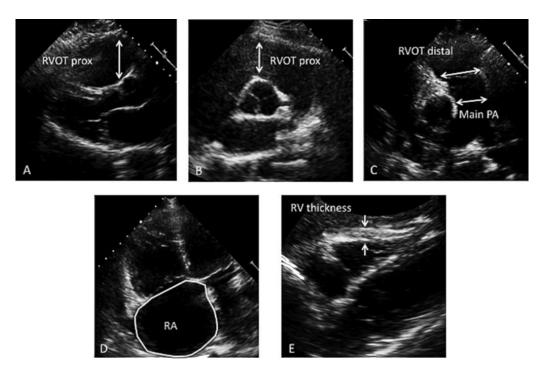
Examples of 2-dimensional echocardiographic chamber dimensions and RV wall thickness. A, Parasternal long-axis view and the proximal RVOT diameter. B, Basal parasternal short-axis view and the proximal RVOT diameter. C, Parasternal short-axis view of the pulmonary bifurcation and the main PA measurement. The RVOT distal measurement is made in this view just above the pulmonary valve. D, Right atrial volume in the apical 4-chamber view in end-systole when the RA has the largest area. E, RV wall thickness, measured in the subcostal view at end-diastole. PA: pulmonary artery; RA: right atrium; RV: right ventricular; RVOT: RV outflow tract.
